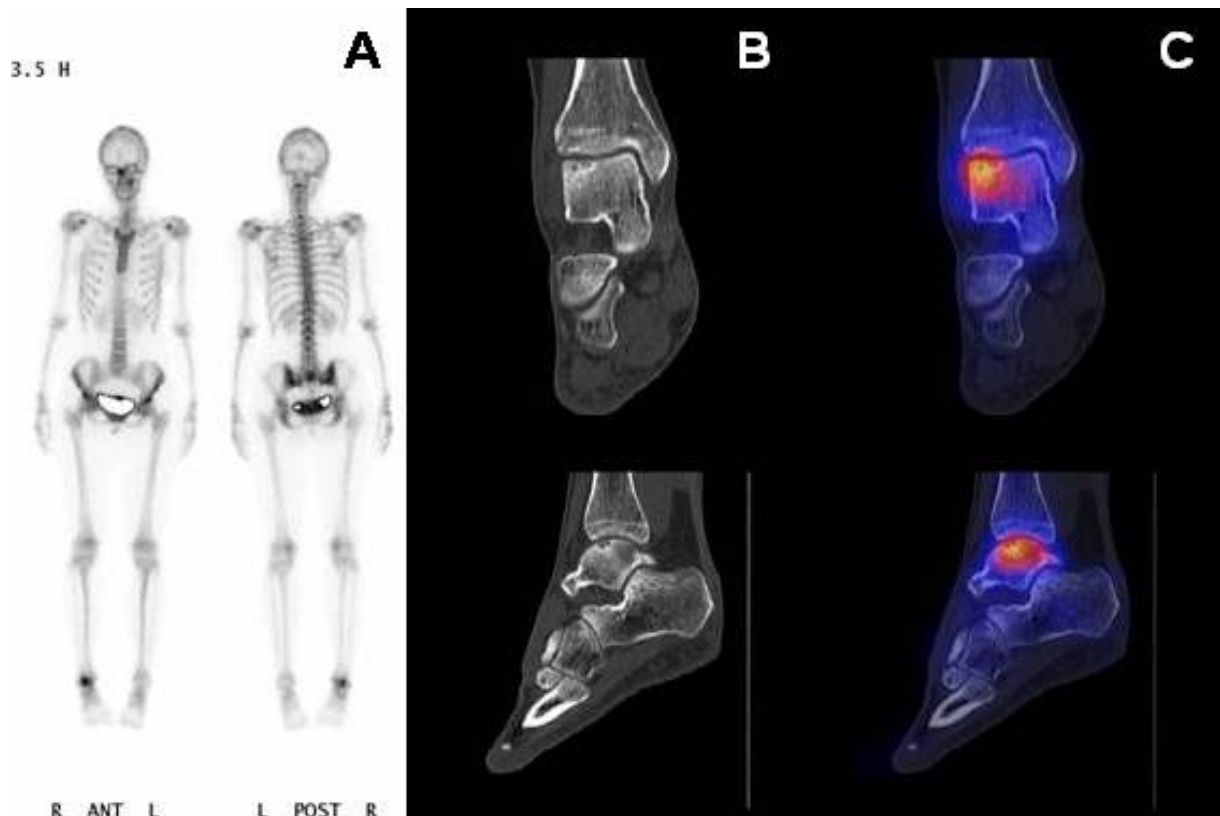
SPECT-CT. Ein SPECT-CT wird als digitale Fusion (C) einer dreidimensionalen Szintigraphie (A) und einer Computertomographie (B) hergestellt.
